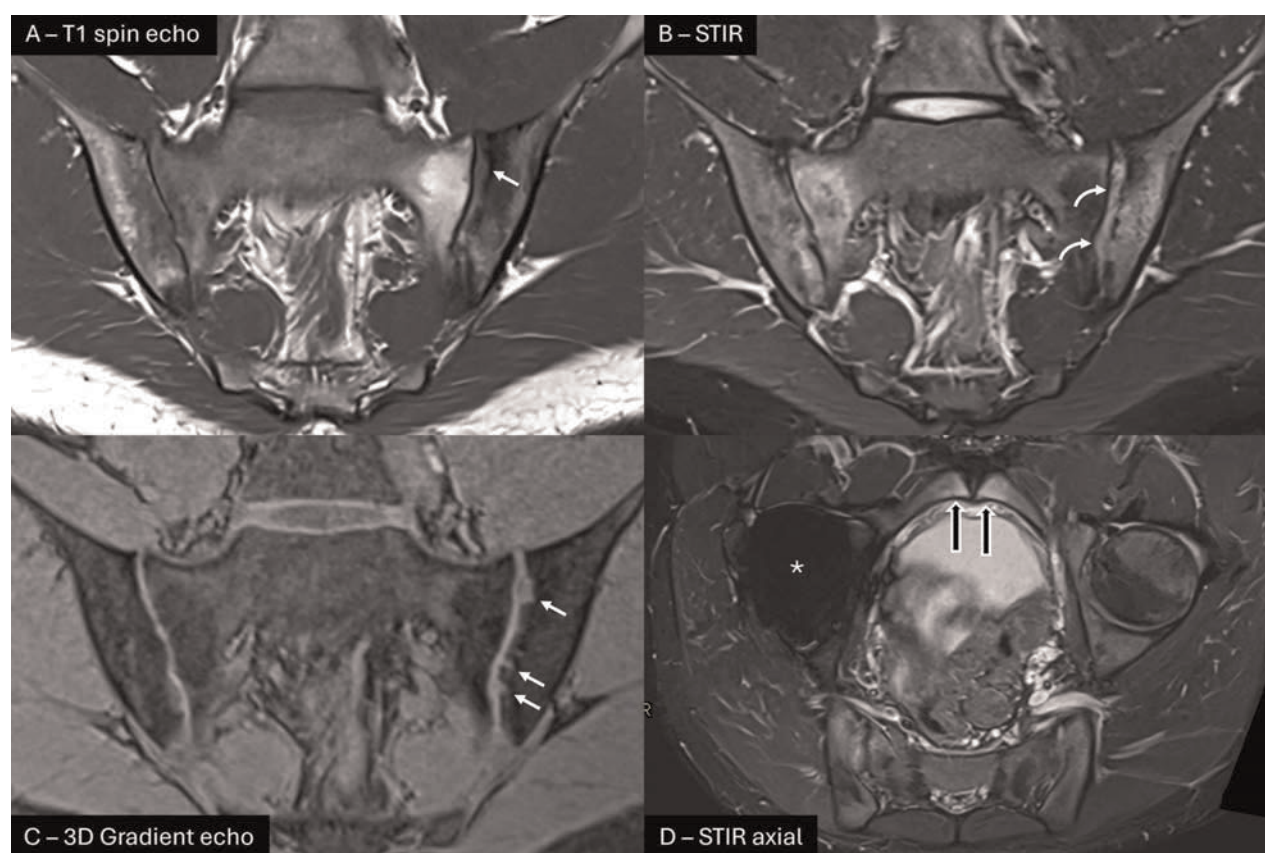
On semicoronal T1 spin echo (a), iliac erosion (arrow) with joint space widening and fat metaplasia in sacral subchondral bone are evident in the left sacroiliac joint. Subchondral bone marrow oedema (BME) is present in the right SIJ and left ilium with decreased signal on T1 and increased signal on STIR (b and d). Semicoronal STIR (b) also demonstrates 'inflammation in an erosion cavity' (curved arrows) with increased signal intensity in the usual location of the articular cartilage that is lower intensity than would be expected for joint effusion. There is no evidence of capsulitis. Semicoronal thin slice 3D gradient echo (c) enhances contrast at the bone/cartilage interface and reveals more erosion in the left SIJ (arrows) than is apparent on the T1 spin echo. A semiaxial T2-weighted sequence incorporating fat suppression (d – STIR), is performed perpendicular to the semicoronal sequences and completes the protocol. In this case, including the pubic symphysis demonstrates symphysitis with bilateral inflammation in the pubic bodies (arrows). A total arthroplasty of the right hip joint, performed for severe inflammatory arthropathy, causes signal loss in the right femoral head (asterisk). SIJ, sacroiliac joint.
